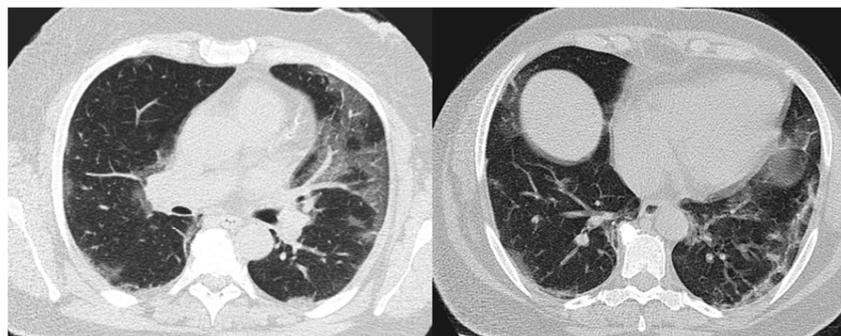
47-year-old female patient with COVID-19. The CT was performed on day 14 of COVID (phase 4), showing a combination of patterns, with the presence of ground glass opacities and architectural distortion.
